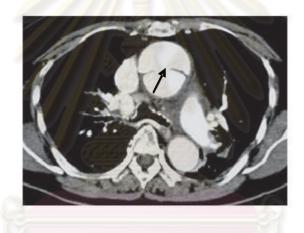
CTA at level of ascending aorta shows type-A dissection with discontinuous dissection flap representing "intimal tear" (*arrow*).
